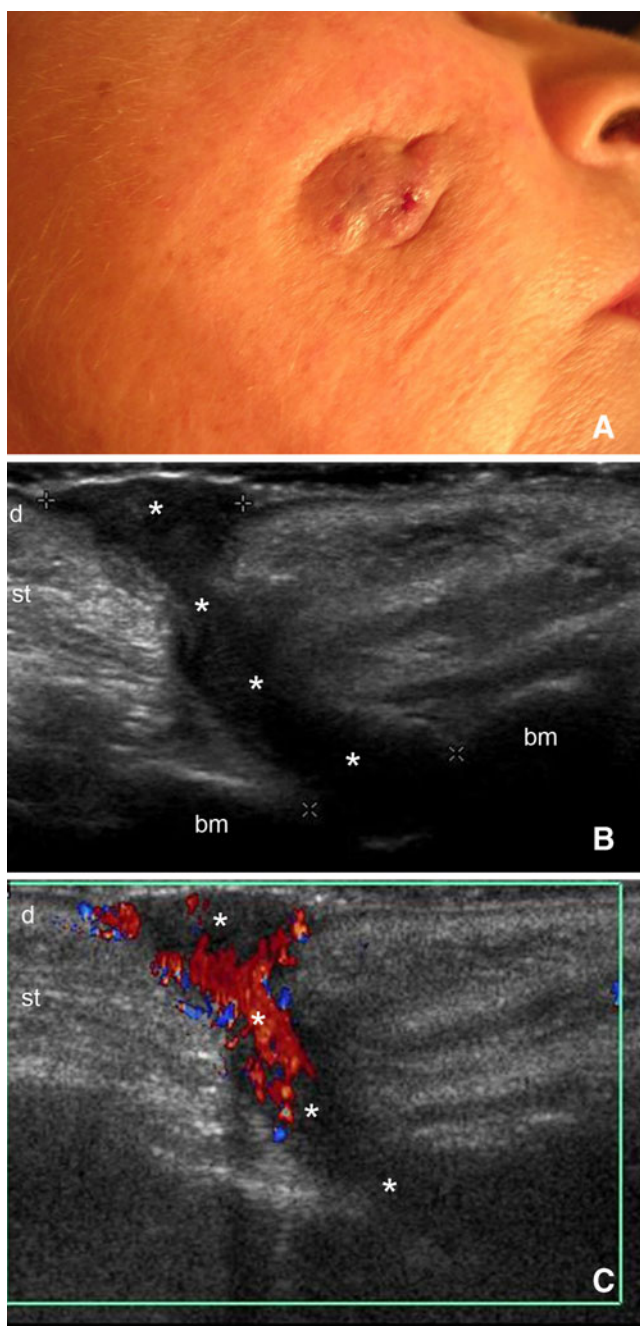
(A, B) Odontogenic fistula. A Clinical lesion in the right cheek. B Ultrasound (transverse view) shows a fistulous tract (asterisks) connecting the skin to the bony margin of the upper maxilla. C. Color Doppler ultrasound (transverse view) demonstrates increased blood flow within the fistulous tract. Abbreviations: *d* dermis, *st* subcutaneous tissue, *bm* bony margin
